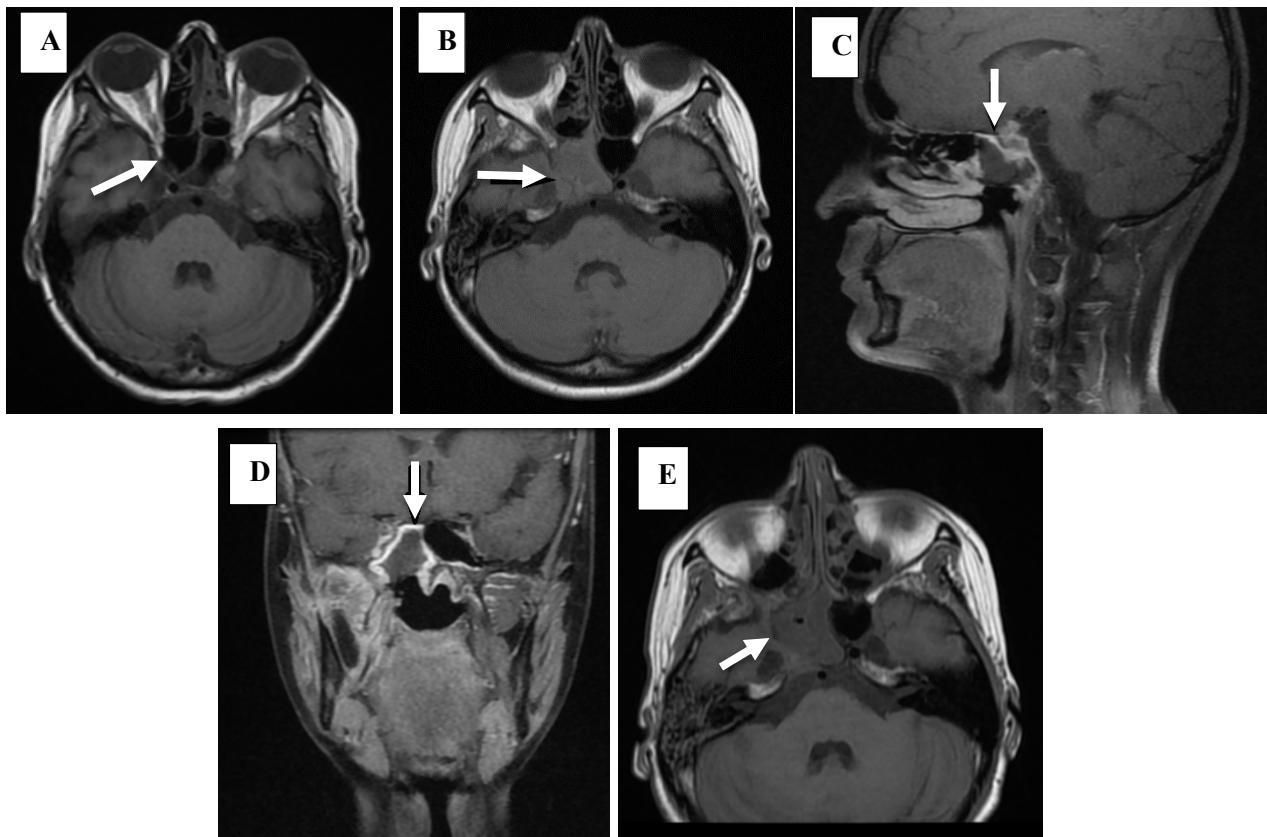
Cranial MRI findings at the onset of the first symptoms on 01.06.2022 (A), on the 69th day of liposomal amphotericin B treatment on 09.08.2022 (B, C and D) and on the 5th month of antifungal treatment on 02.11.2022 (E)
